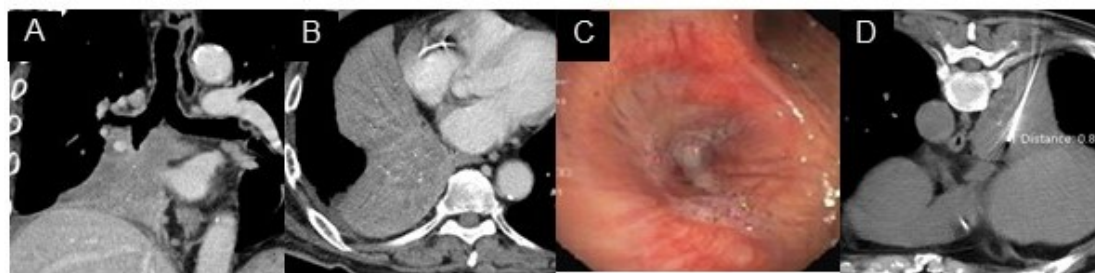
An 85-year-old male presented with chronic cough for 1 year. Coronal (A) and axial (B) contrast-enhanced CT chest showed abrupt occlusion of right bronchus intermedius with consolidation involving RML and RLL. (C) Bronchoscopy revealed mass at right bronchus intermedius with contact bleeding. The pathological result from bronchial washing showed only reactive pneumocytes with necrotic debris and sparse inflammation. (D) CT chest during the TTNB showing the biopsy needle in the target lesion. The pathological result from CNB was squamous cell carcinoma.
